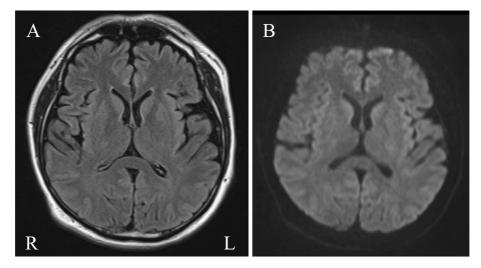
Cerebral magnetic resonance imaging (MRI) findings. Cerebral MRI fluid attenuated inversion recovery (FLAIR, A) and diffusion-weighted imaging (DWI, B) images on day 1 did not reveal any abnormalities in the brain. These abnormalities could not even be observed in the left frontotemporal region, in which electroencephalographic abnormalities had been confirmed. R: right side, L: left side
